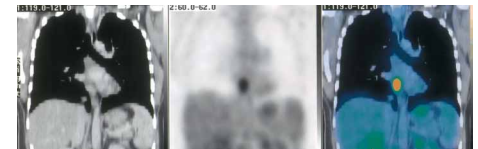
Fusion of the chest CT and PET coronal imaging shows the abnormal activity in the paraesophageal area.
